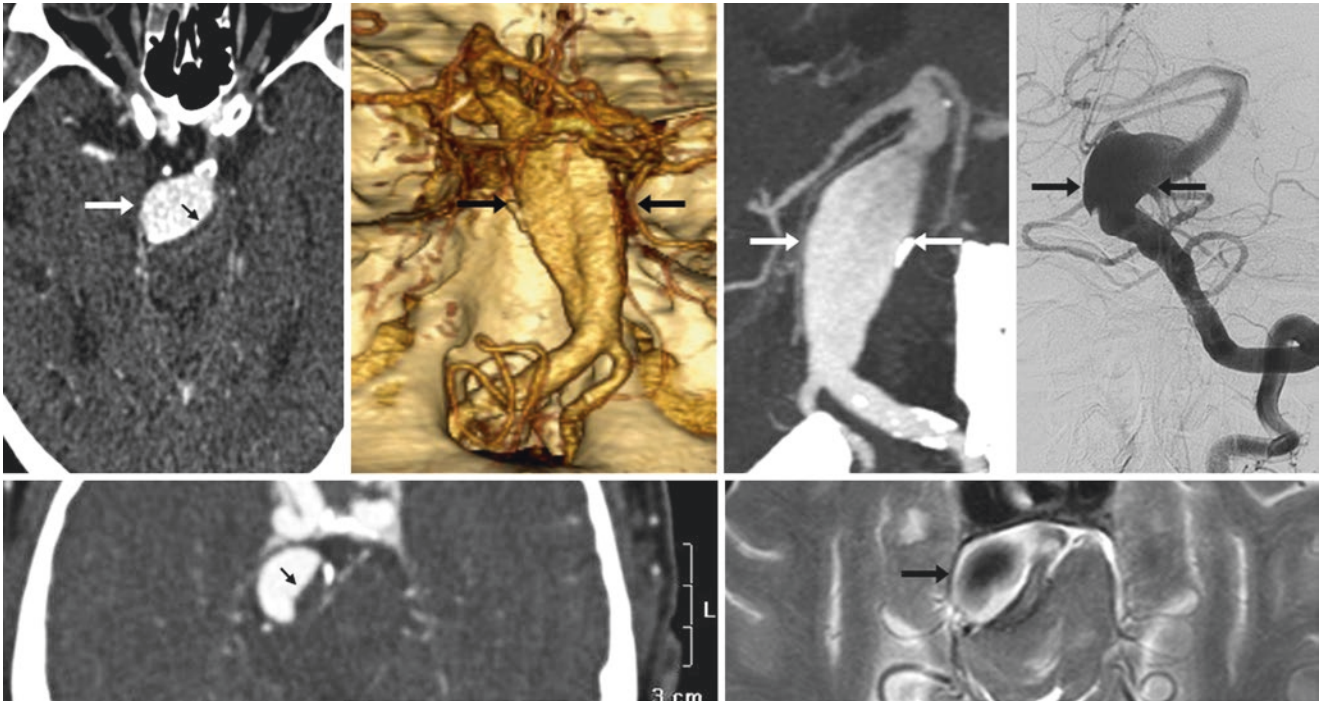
Comparison case of a dissecting VBA aneurysm. *Top row:* A 69-year-old with CN VI symptoms had severe, fusiform VBA enlargement (*large arrows*) with a clot within the lumen of the aneurysm (*thin arrow*) on CTA source images (*left*), 3D VR PA view (*left middle*) and coronal MPR (*right middle*), and on catheter DSA (*right*). *Bottom row:* Three months later, the size of the clot had increased on CTA (*left*); T2WI MRI (*right*) demonstrates a partial flow void
